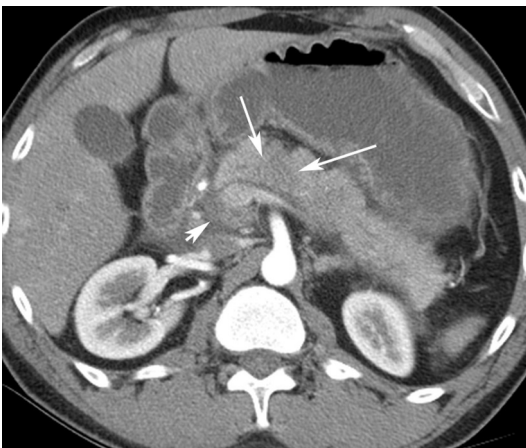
Acute interstitial edematous pancreatitis for 24 hours. A CT image in the axial plane of a 22-year-old man shows a swollen and edematous pancreas with stranding and a small amount of APFC (*short arrow*). A focal area of decreased perfusion (*long arrows*) is identified in the body of the pancreas. This likely represents focal edema but could be confused with necrosis at this early stage. It should be considered indeterminate. A follow-up CT study after 7 days demonstrated absence of necrosis.
